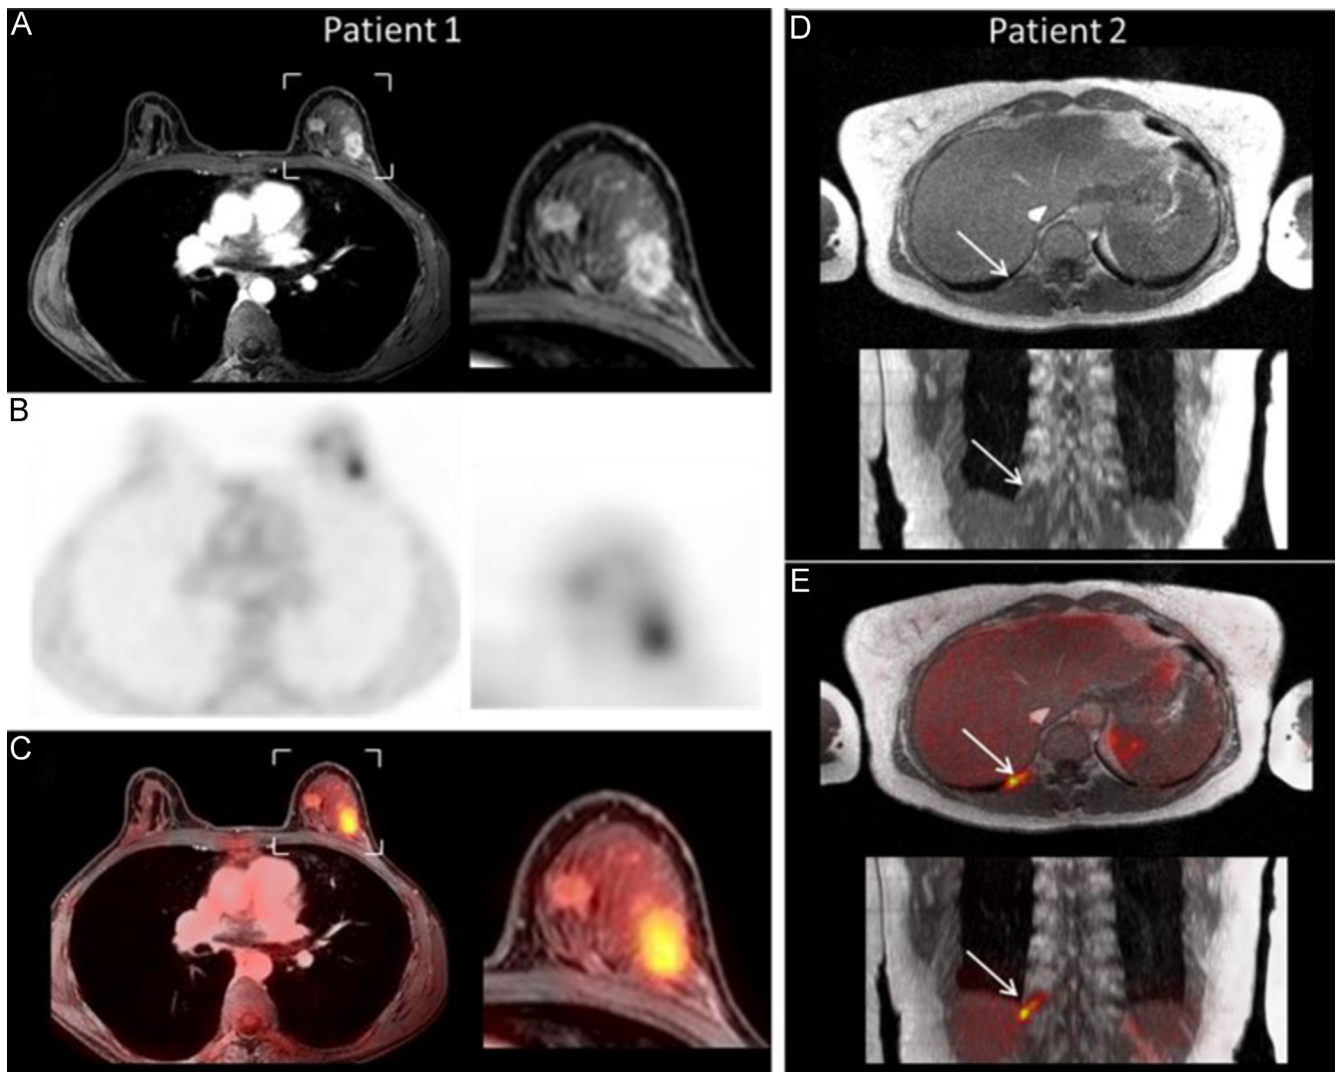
Examples of hybrid PET/MR studies conducted on a Philips Ingenuity TF PET/MR using a dedicated seven channels breast coil for local and distant metastatic assessment of breast cancer: (patient one) 35-year-old woman with grade 2 invasive ductal carcinoma (IDC): PET showed uptake in two sites (B), one corresponding to the known IDC, the second, less obvious on PET, being highly suspicious on DIXON-water images 90 seconds after using gadolinium (A) and on fusion of Dixon and PET images (C). This second lesion was confirmed to be an IDC on biopsy; (patient two) 46-year-old woman with left breast IDC: suspicious osseous ^{18}F -FDG uptake (D and E: white arrows), clearly visible on PET images (E), and retrospectively identified on whole-body in-phase Dixon MRI (D). The diagnosis of bone metastasis was confirmed with a biopsy.
